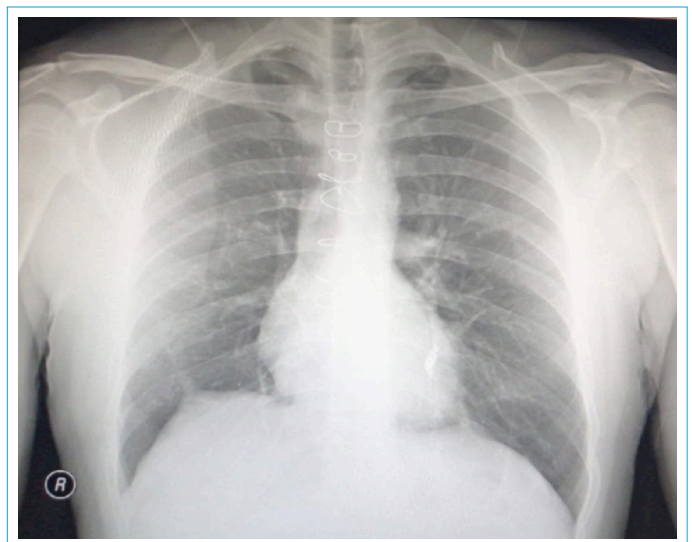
Control X-ray chest radiograph.
